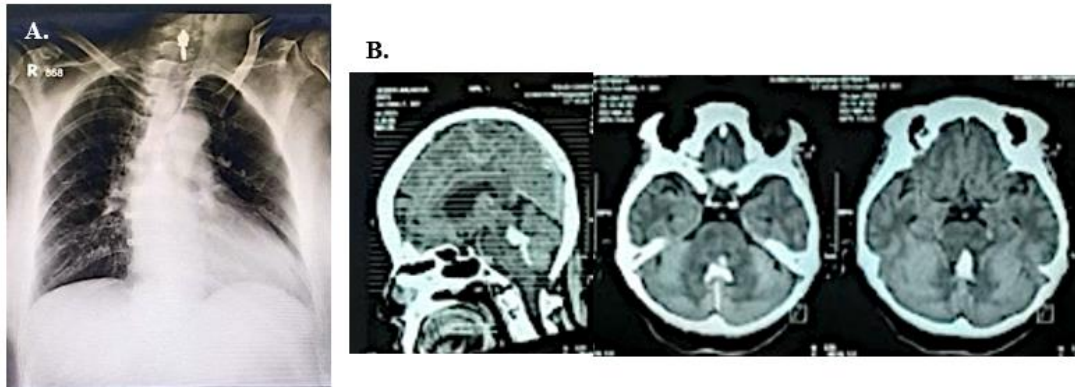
Diagnostic tests for the first patient. A) Chest X-ray results. B) Non-contrast head CT-scan results.
